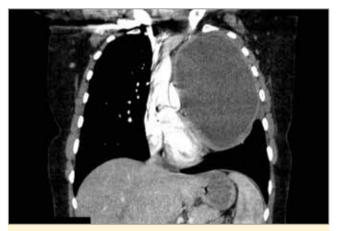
Chest–CT with giant hydatid cyst of the upper left pulmonary lobe.
